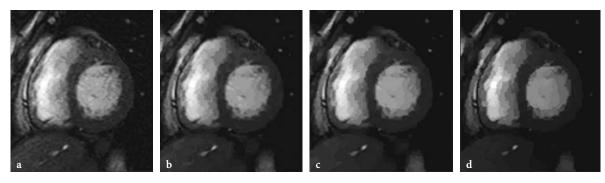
Anisotropic filtering of MRI cardiac images. Images from left to right show the effects of different (different K-values) strengths of the filtering operation
